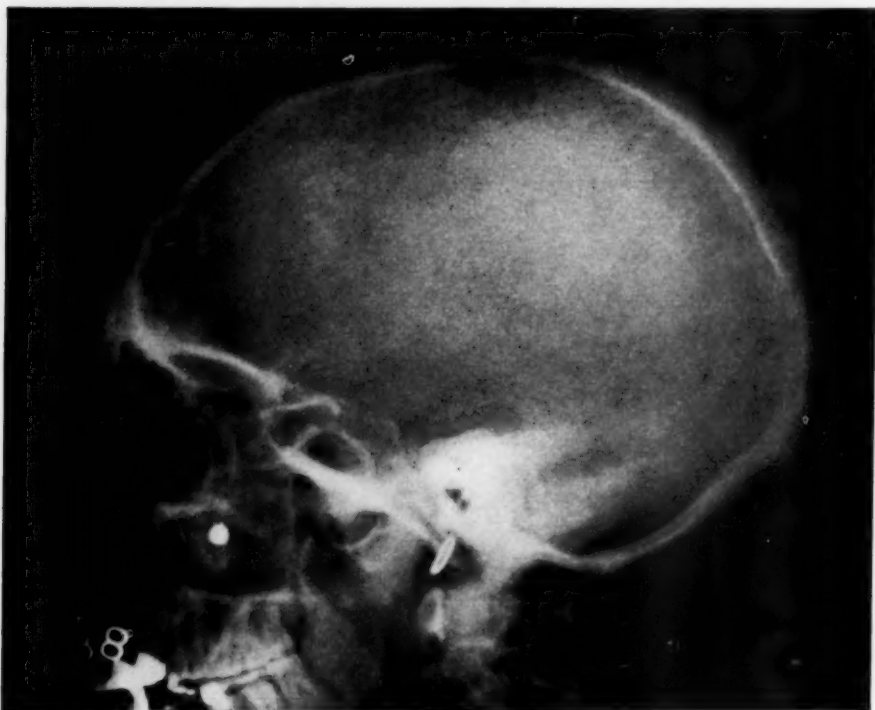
Roentgenogram of the skull.
